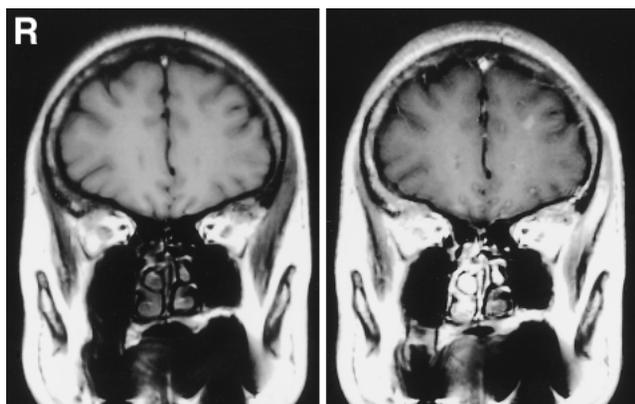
T₁-weighted magnetic resonance images showing an isointense mass in the temporal muscle (left) with heterogeneous enhancement by gadolinium (right).
